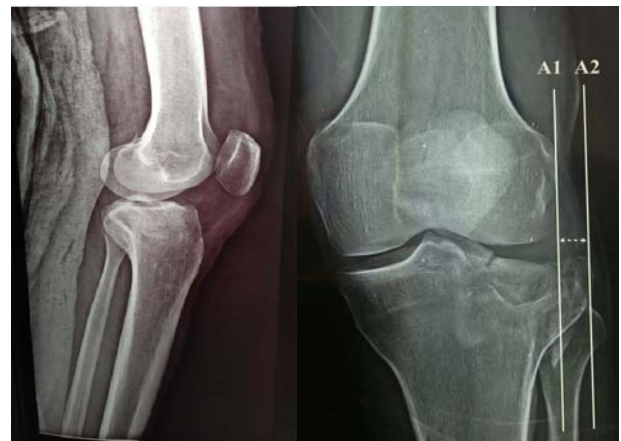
Routine plain X-ray (A-P & lateral views)
